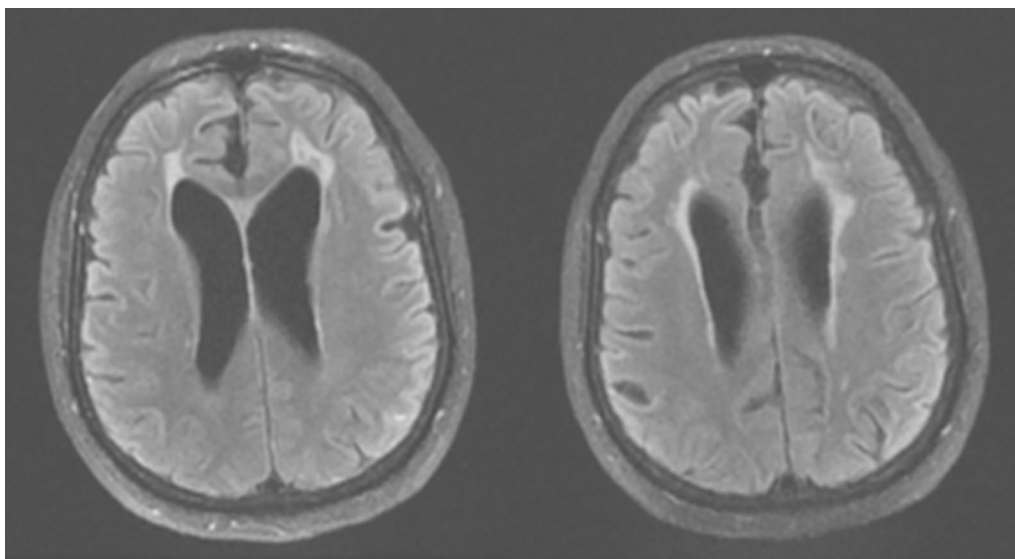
The axial FLAIR MRI showed moderate dilatation of both lateral ventricles, surrounded by high signal intensity along with ependymal, suggesting ventriculitis
